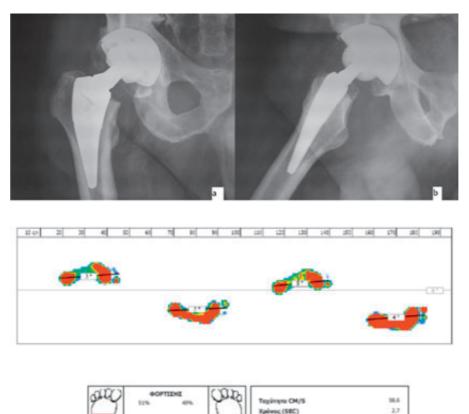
Big femoral head arthtroplasty radiographs: (a) AP, (b) lateral and postoperative gait analysis.
